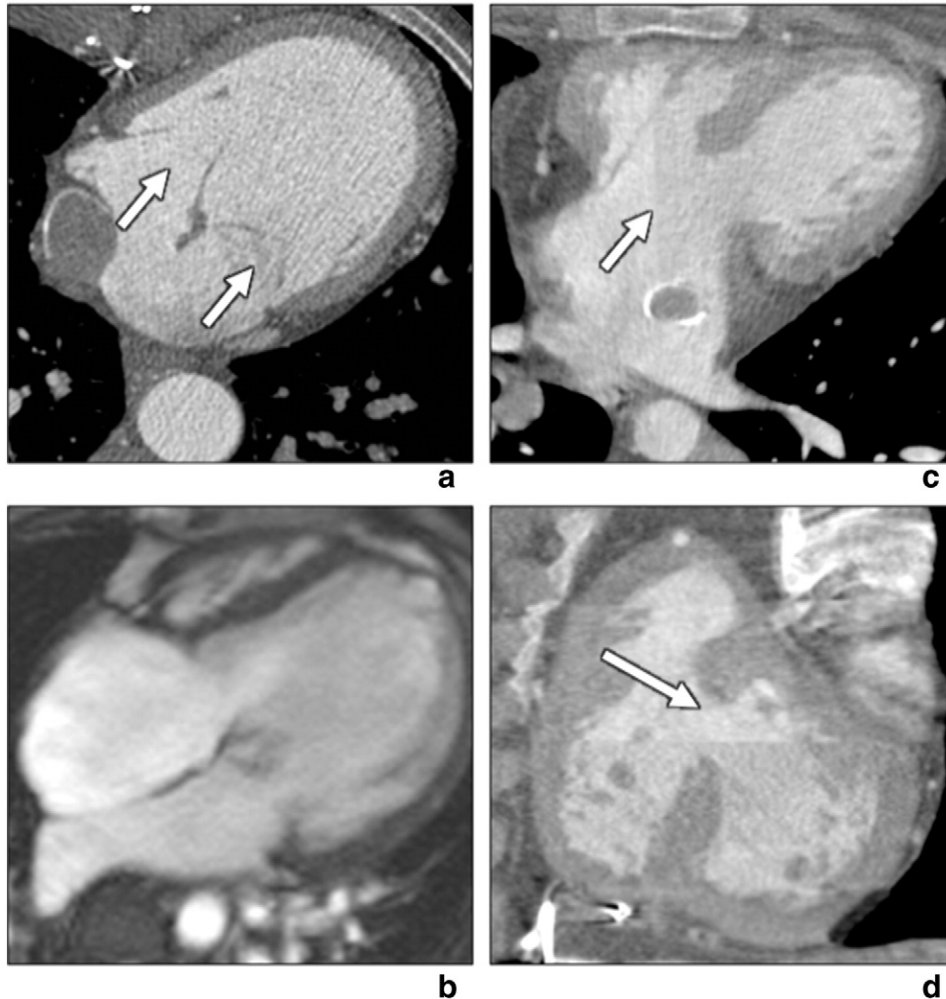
Single functional ventricle lesions with a dominant left heart. DILV seen on axial CT (a) and four-chamber magnetic resonance (b) images. Both AV canal valves (arrows) are connecting to dominant left ventricle. Note the smooth border of the ventricle, which defines it as an LV. An unbalanced atrioventricular defect (arrow) seen on CT four-chamber (c) and short-axis (d). Images show a dominant left ventricle (*) and large VSD (arrow).
